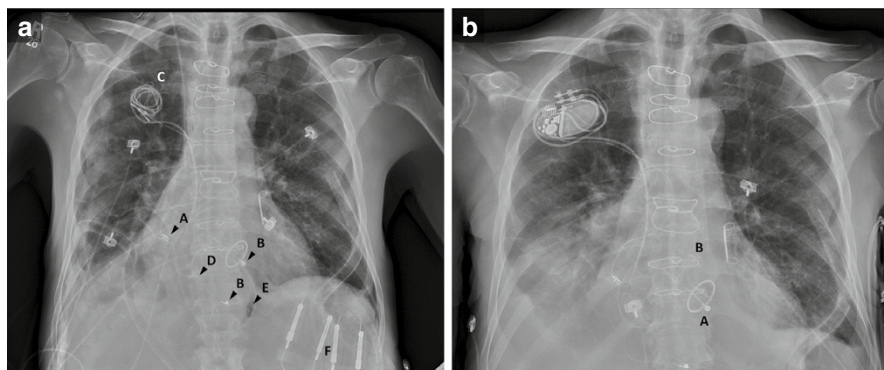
(a) Chest X-ray showing permanent epicardial pacing leads in the right atrium (A, screwed helix) and right ventricle (B, two pacing poles) tunneled to the right chest (C) in a pacer-dependent patient who underwent aortic valve replacement due to endocarditis and required system extraction intraoperatively. Temporary epicardial pacing leads were also placed in the right atrium (D) and right ventricle (E), and externalized to be connected to a portable pacing unit (F). (b) Once cultures cleared, permanent pacemaker generator was implanted in the right chest. Note that this patient had prior mechanical mitral valve replacement (A) in addition to bioprosthetic aortic valve replacement (B)
